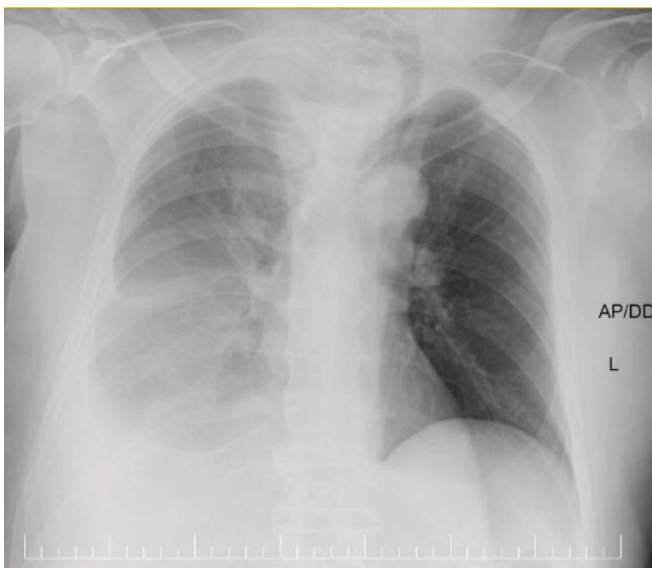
Chest radiograph: right pleural effusion.
